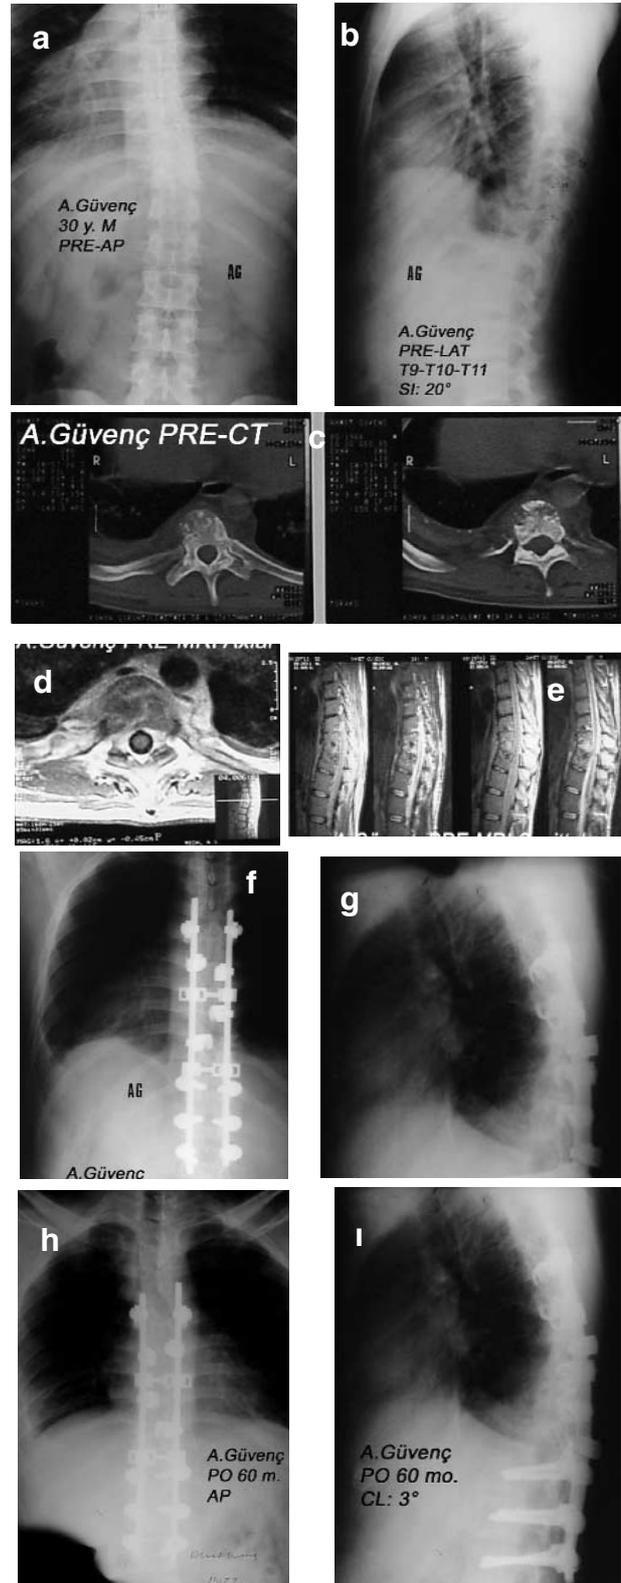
Preoperative posterior-anterior (a), lateral (b) graphics, CT images (c), axial MR (d) and sagittal MR (e) images of the patient (AG) treated with posterior instrumentation.
